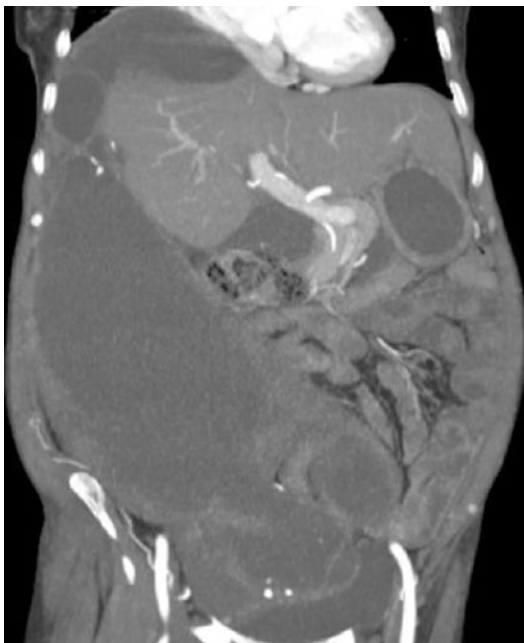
Compartmentalization of the small bowel on CT scan—the small bowel is pushed to the left upper quadrant of the abdomen but is uninvolved by tumour
